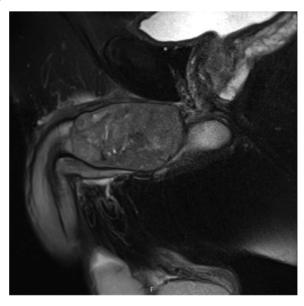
Sagittal view of pelvis MRI. MRI of the pelvis demonstrated the right corpus cavernosum mass causing external compression of the urethra, leading to the patient's lower urinary tract obstructive symptoms.
